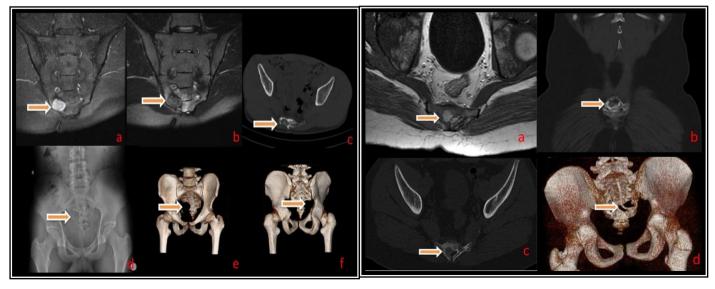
a) Preoperative MRI, b) Preoperative MRI, c) Preoperative CT, d) Preoperative standard x-ray, e) Postoperative CT AP, f) Postoperative CT PA
